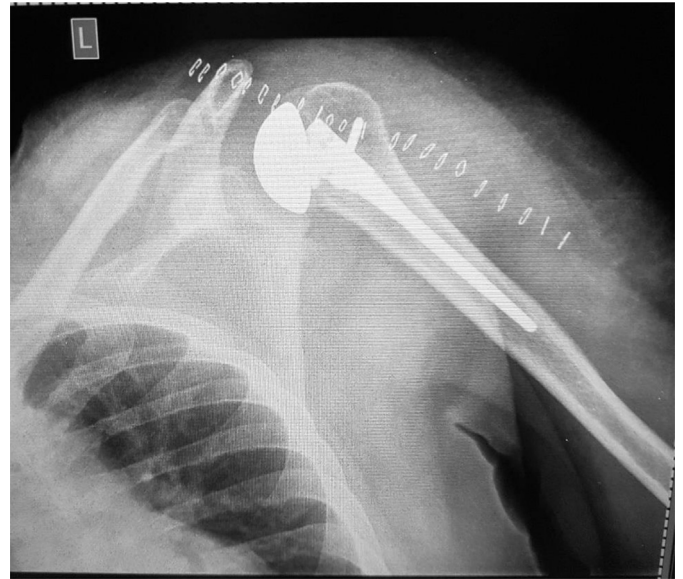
Initial postoperative radiographs of the left shoulder hemiarthroplasty.
